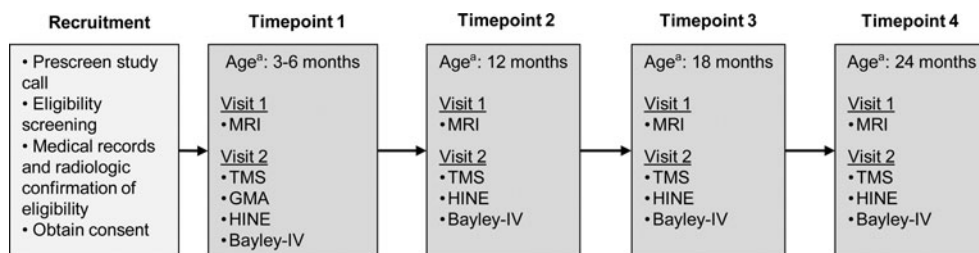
Study design and assessment schedule. MRI indicates magnetic resonance imaging; GMA, General Movements Assessment; HINE, Hammersmith Infant Neurological Examination; TMS, transcranial magnetic stimulation; Bayley-IV, Bayley Scales of Infant and Toddler Development IV. ^aAge corrected for prematurity.
